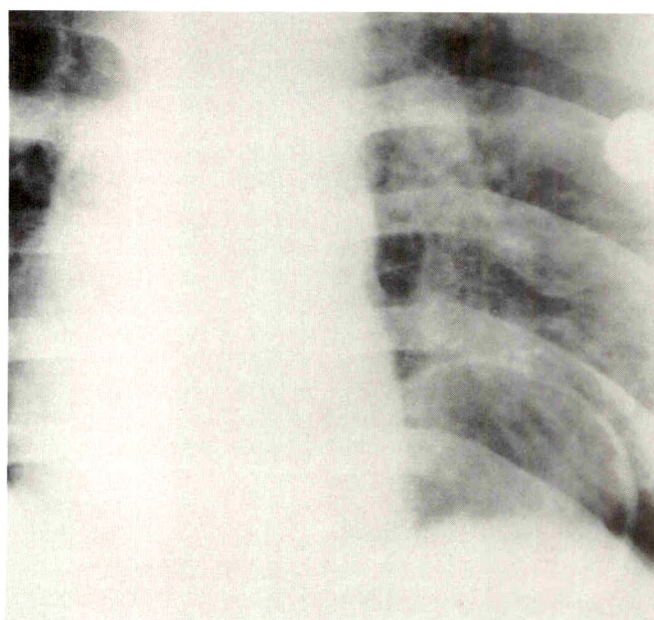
Chest radiograph shows a circular air lucency projecting above left hemidiaphragm, which appears to be in a normal position. Mediastinal shift toward right side is noted. Surgery revealed left hemidiaphragm rupture with herniation of colon into left hemithorax.
